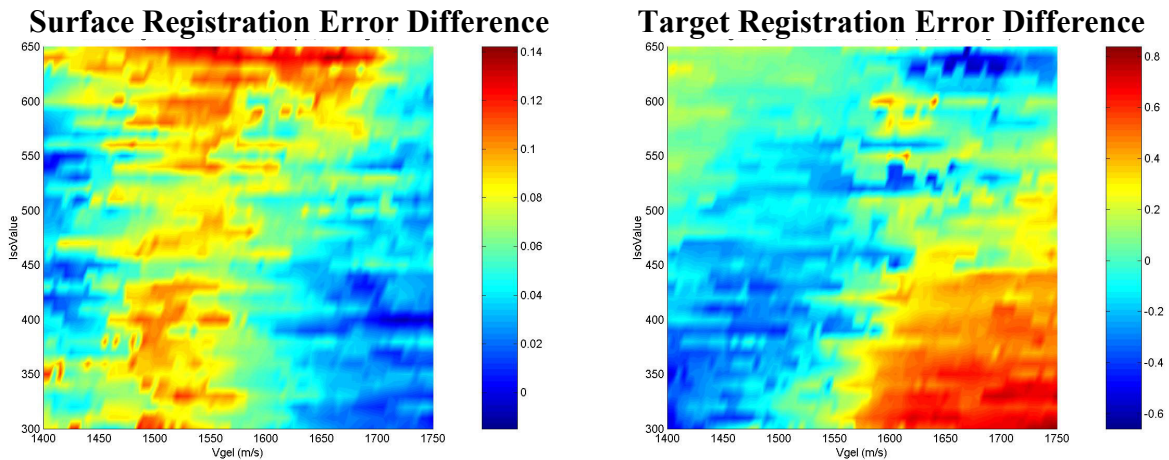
Differences in the registration errors between simplified surfaces Model C (based on the original CT volume) and Model F (based on the CT4 volume). (a) surface registration error difference between a model created from 2 mm slices and a model created from 4mm slices vs. isointensity parameter and speed of sound in gelatin, (b) target registration error difference vs. isointensity parameter and speed of sound in gelatin. All registration errors have units of mm.
